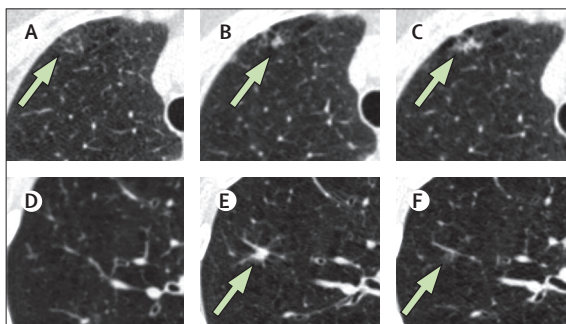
Lung nodules identified on lung cancer screening low-dose CT in two patients
